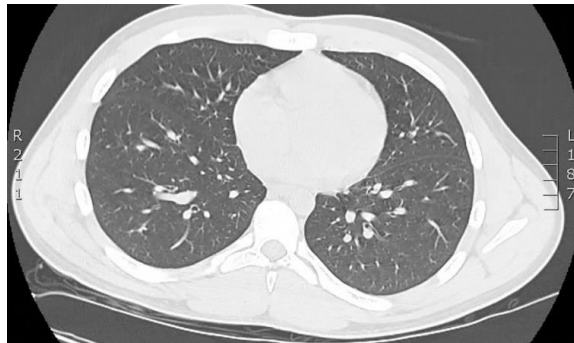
Chest CT confirming findings consistent with COVID-19.
